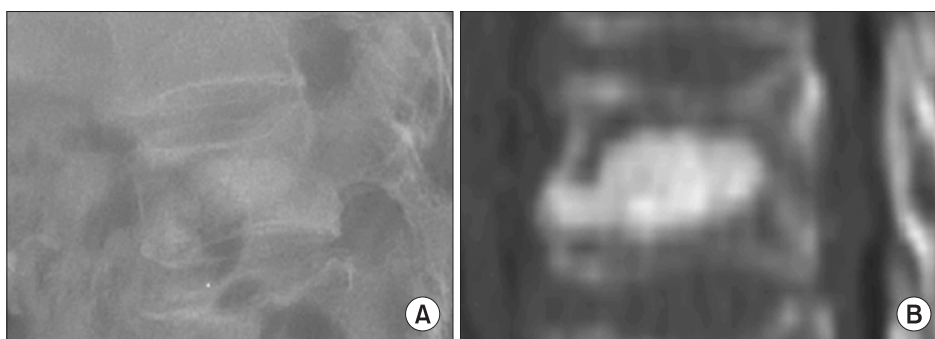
Simple radiography (A) and computed tomography scan (B) show fracture site of vertebral body charged by allogeneic bone chips.
